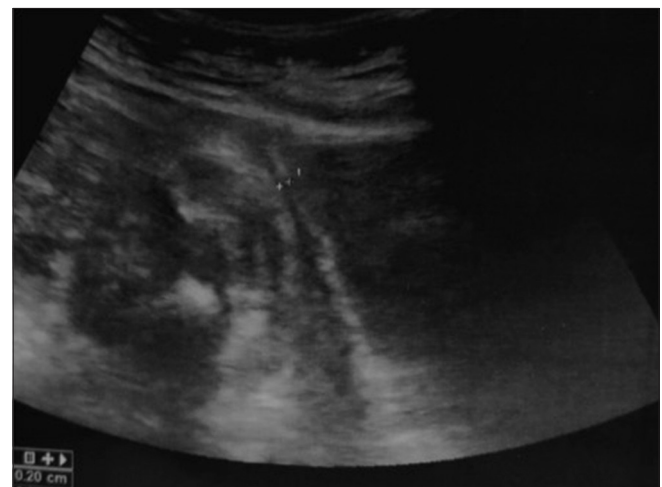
Longitudinal sonographic image showing measurement of scar thickness taken at the thinnest portion of the lower uterine segment
